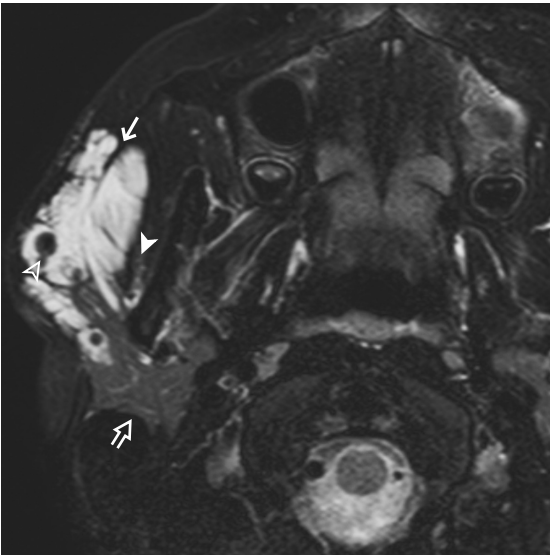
Axial T2W MRI of right parotid region shows an irregular lobulated T2W hyperintense lesion (→) centered in the subcutaneous layer of right face with involvement of right masseter muscle (▲) and superficial lobe of right parotid gland (▲). A rounded T2W hypointense focus (▲) within the lesion is consistent with a phlebolith. Features are consistent with venous vascular malformation.
